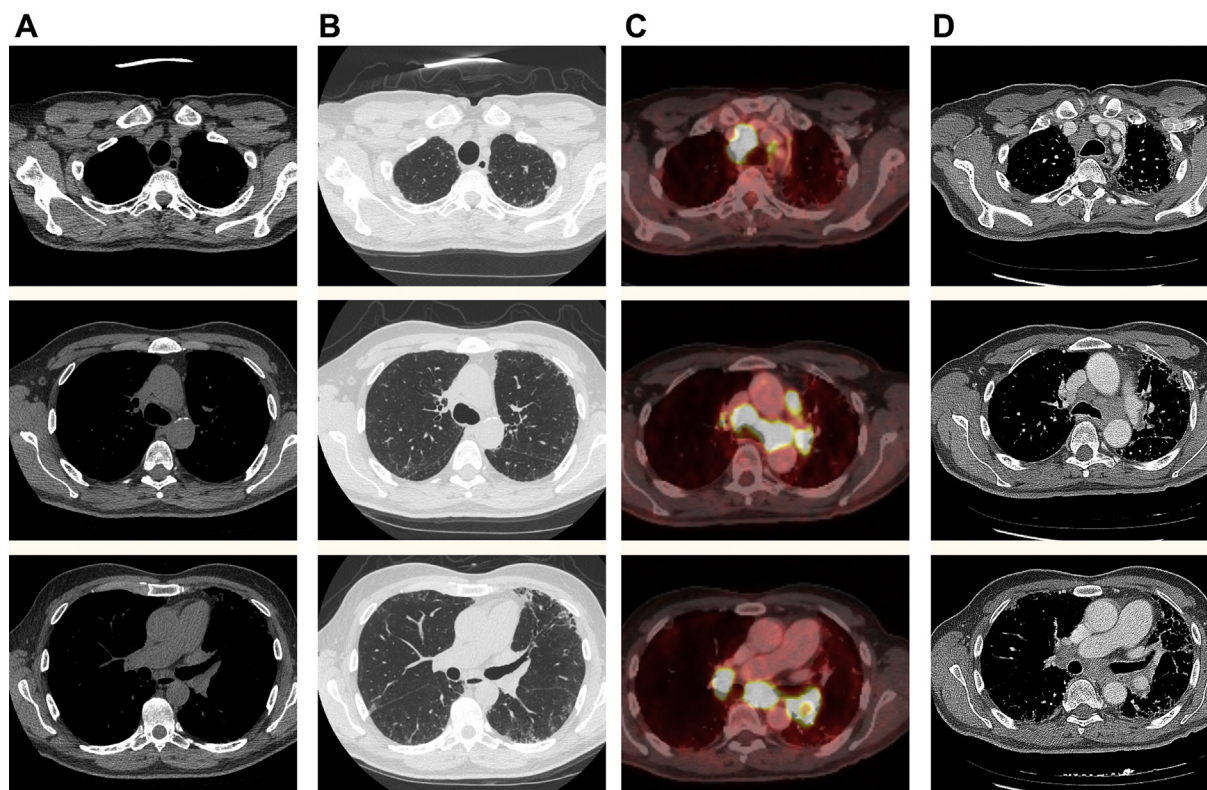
CT and PET CT scans showing development of diffuse hypermetabolic lymphadenopathy after starting pirfenidone. A, Soft tissue window prior to starting pirfenidone. B, Lung window prior to starting pirfenidone. C, PET-CT after starting pirfenidone. D, Soft tissue window after starting pirfenidone.
